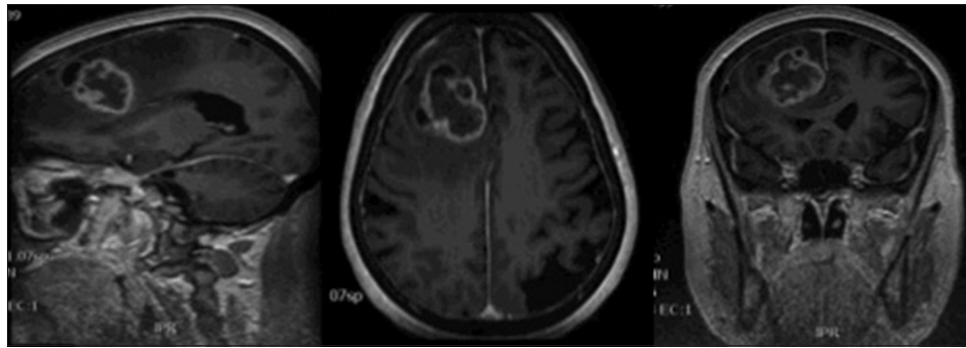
Preoperative neuroimaging of a right frontal glioblastoma. Gadolinium enhanced T1 weighted brain magnetic resonance imaging (MRI)
